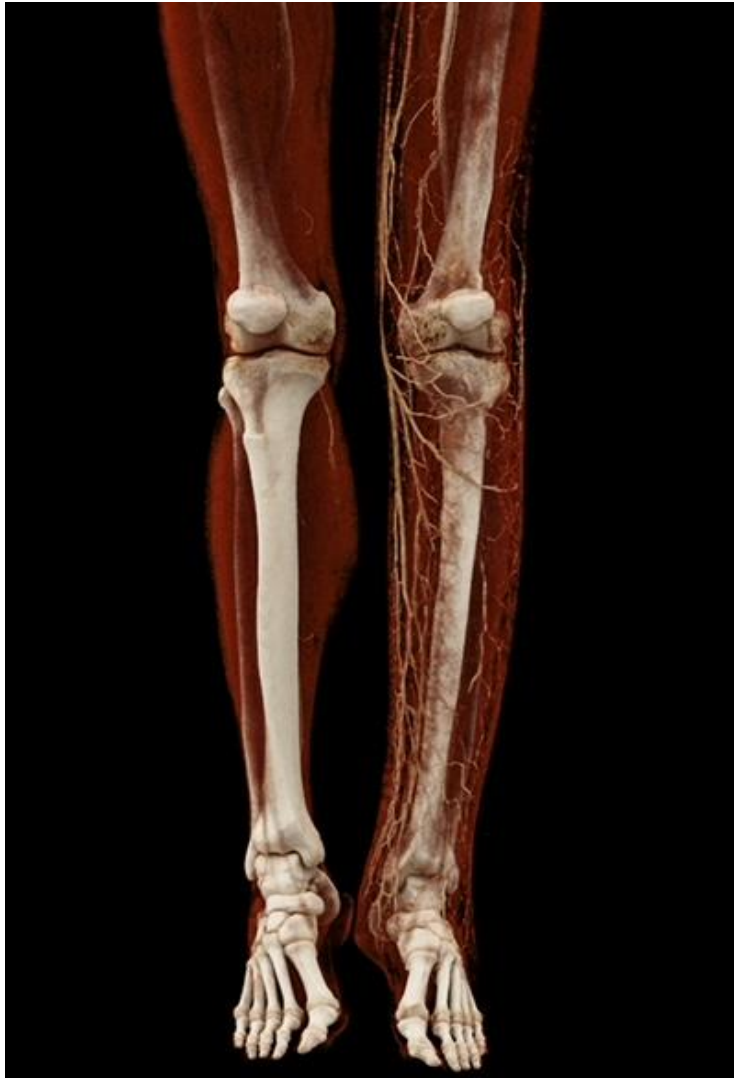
CT VR, numerous spreading vascular structures in the subcutaneous tissue of the left thigh and lower leg. Intensified vascular network in the midshaft of the left femur, tibia, and fibula. Generalized atrophy in the muscle structures of the left thigh and lower leg.
